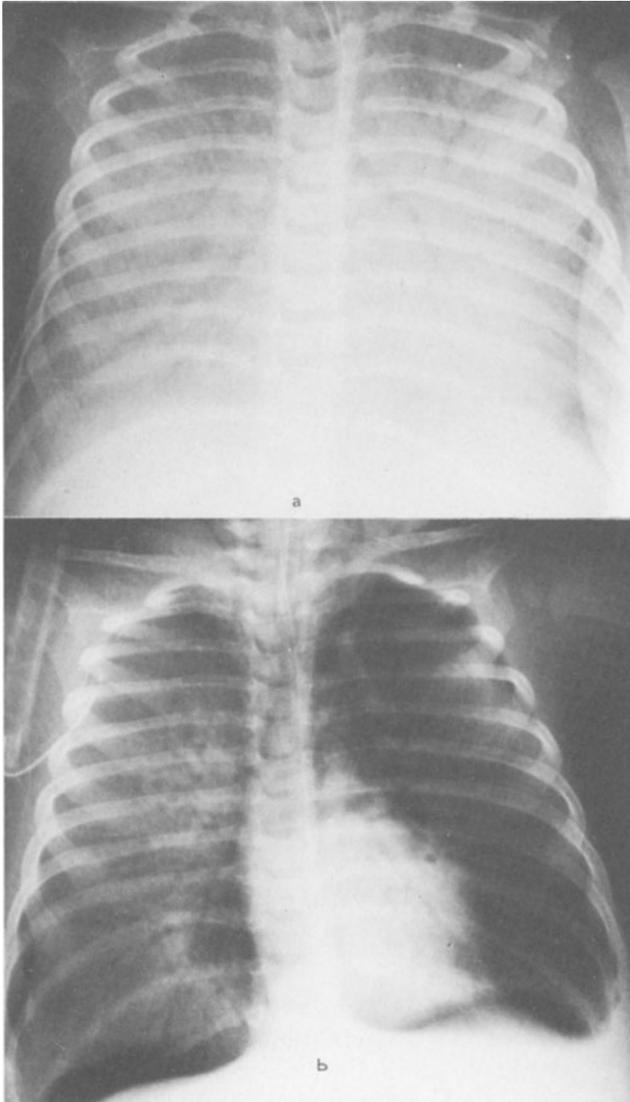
a, b. X-rays from a child with a severe ARDS immediately before (a) and 4 hr after surfactant replacement therapy (b)
